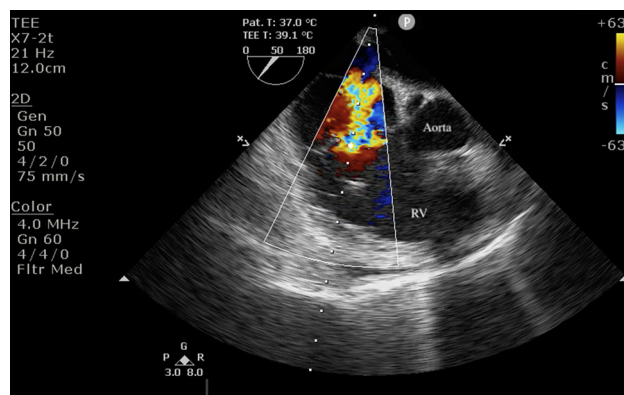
Transesophageal right ventricular inflow-outflow view showing severe tricuspid regurgitation
